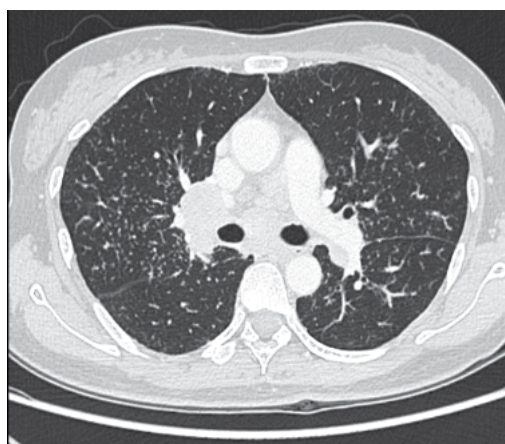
Chest CT scan shows typical perilymphatic distribution of micronodules.
